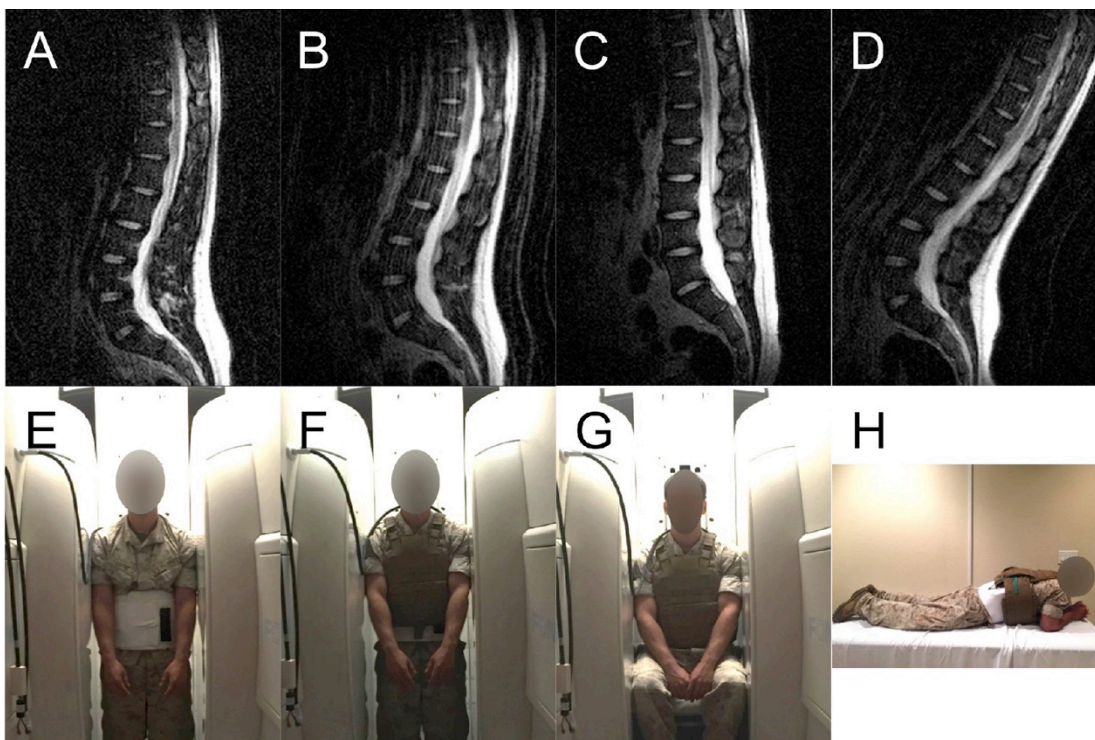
T2-weighted mid-sagittal magnetic resonance images (MRIs) of the lumbar spine (top) and photographs of Marines in the MRI scanner (bottom). Volunteers were scanned standing unloaded (A, E), standing with body armor (B, F), sitting with body armor (C, G), and prone on elbows with body armor (D, H).
